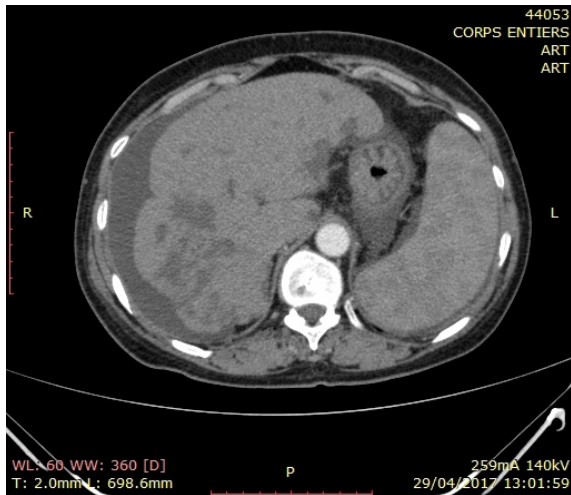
CT scan of the liver showing a heterogeneous and dysmorphic liver with bosselated contour and a major atrophy of the right liver lobe
